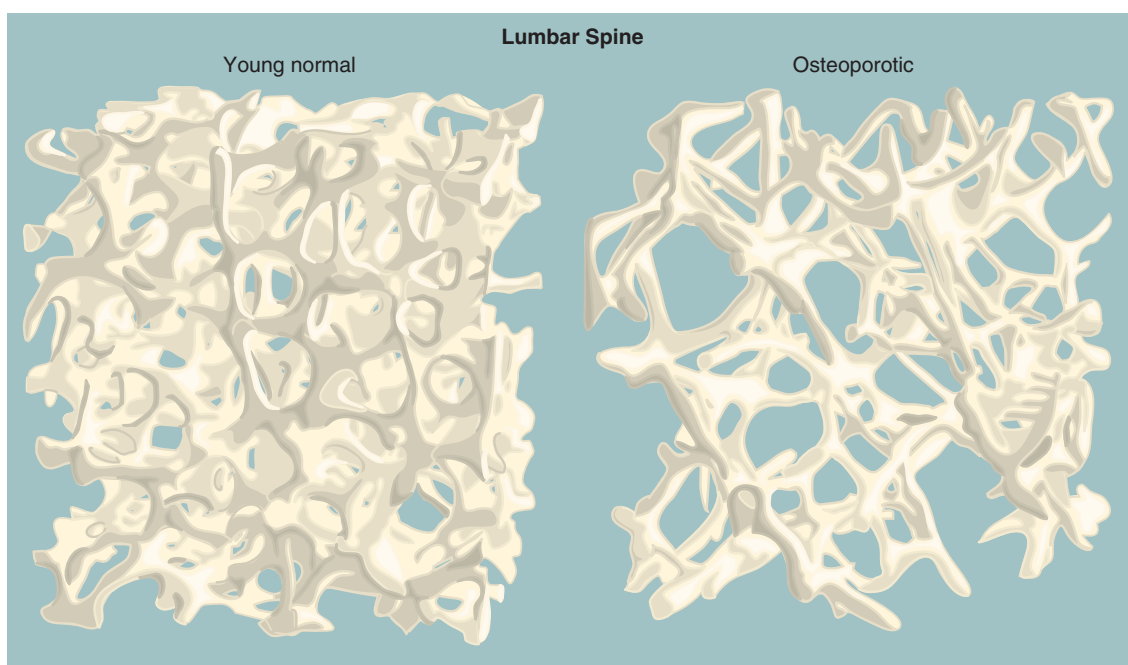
Three-dimensional reconstruction by microcomputed tomography of a lumbar spine sample from a young adult normal woman and from a woman with postmenopausal osteoporosis. In the osteoporotic woman, bone mass is reduced and microarchitectural bone structure is deteriorated. Whereas the platelike structure in the normal case is very isotropic, the structure in the osteoporotic case shows preferential loss of horizontal struts; the plates have become rods that are thin and farther apart, and there is a concomitant loss of trabecular connectivity. These changes lead to a reduction in bone strength that is more than would be predicted by the decrease in bone mineral density. (From Riggs BL, Khosla S, Melton LJ 3rd: Sex steroids and the construction and conservation of the adult skeleton, *Endocr Rev* 23:279–302, 2002; Courtesy Ralph Mueller, PhD, Swiss Federal Institute of Technology [ETH] and University of Zurich, Switzerland.)
